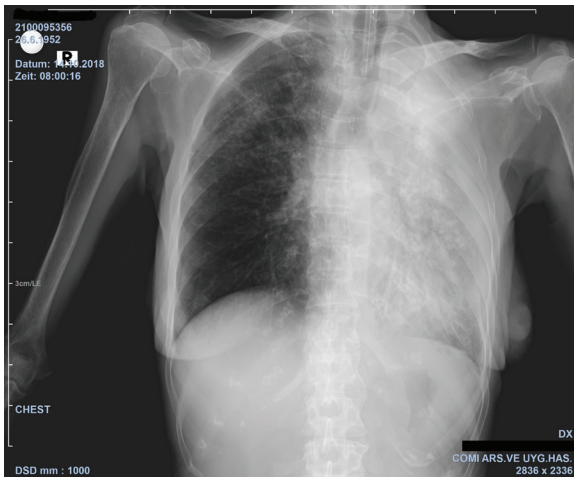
Chest x-ray reveals complete white-out of the left lung due to total atelectasis.
